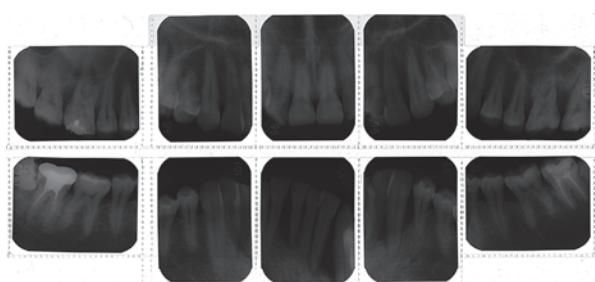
X-ray graph at first examination
